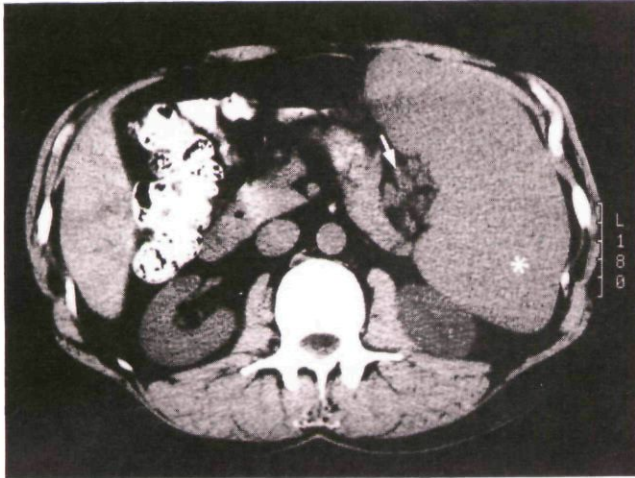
Computed tomographic scan of the abdomen (patient 1) showing enlarged spleen (*) and perisplenic adenopathy (arrow), subsequently confirmed at laparotomy.
